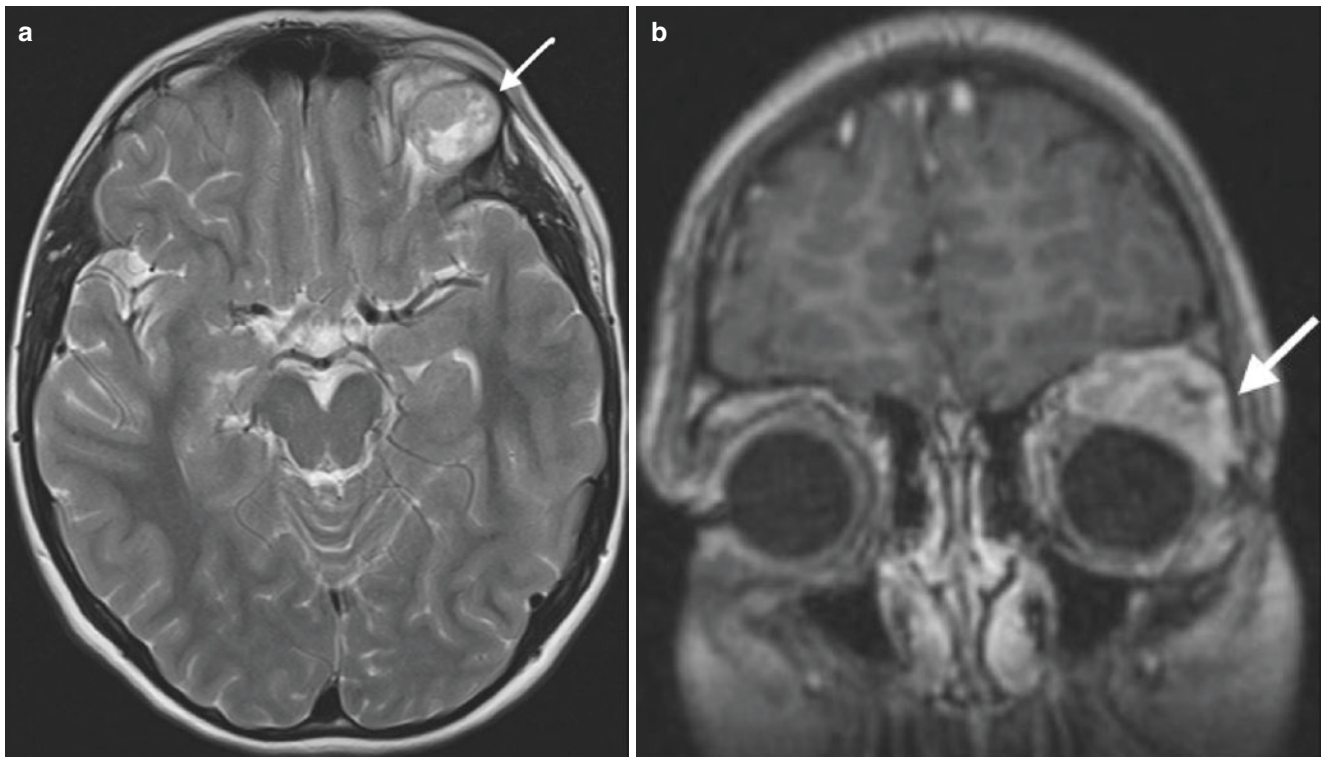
Left orbital rhabdomyosarcoma. (a) Axial T2-weighted MR image shows an isointense to hyperintense lesion in the superior aspect of the left orbit. (b) Coronal post-contrast T1-weighted MR image demonstrates enhancement of the tumour
